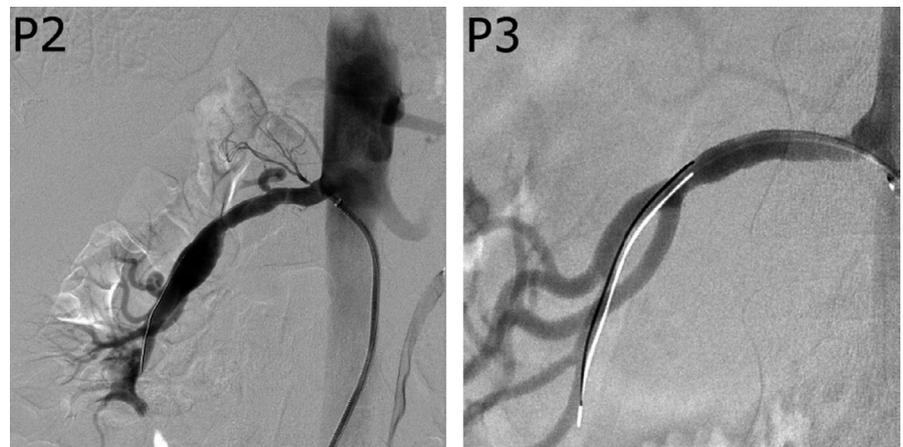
Images of renal artery lesions in FMD (P1, P2, P3, P4, P5) and non-FMD patients (P6, P7). Renal artery lesions were documented with Computed Tomographic Angiography (P1, P4, P5) and catheter-based angiography (P2, P3, P6, P7)
